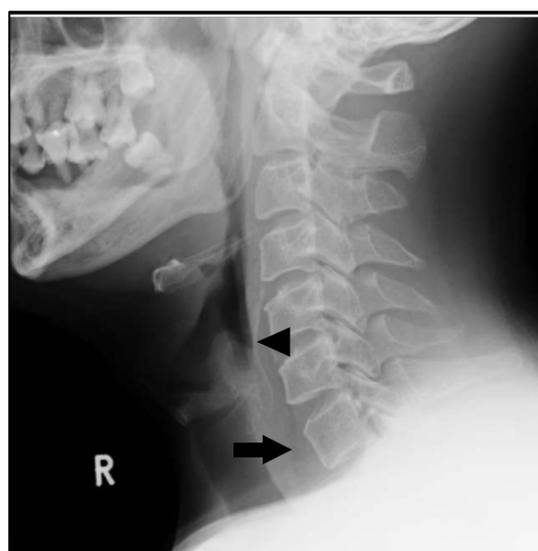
Lateral soft tissue neck X-ray shows long segment of air trapping in the oesophagus (arrow), suggestive of foreign body impaction at the level of C6 and C7 region. Calcified posterior border of thyroid cartilage (arrowhead) may be mistakenly interpreted as foreign body at the level of C5 and C6
